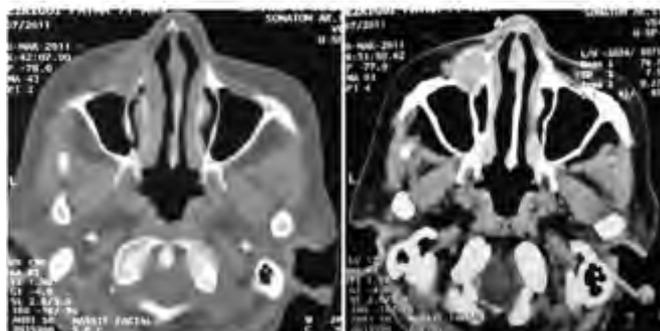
Axial computed tomography of the paranasal sinuses without and post contrast showing a round osteolytic lesion depending of frontal process of the left maxillary sinus (red arrow).
